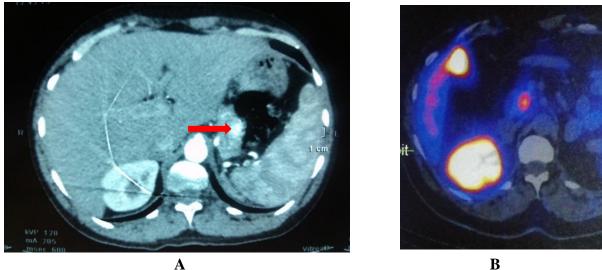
A) Abdominal CT- the red arrow shows the corporeal PNET, B) Octreotid scintigraphy- intense fixation of corporeal PNET
